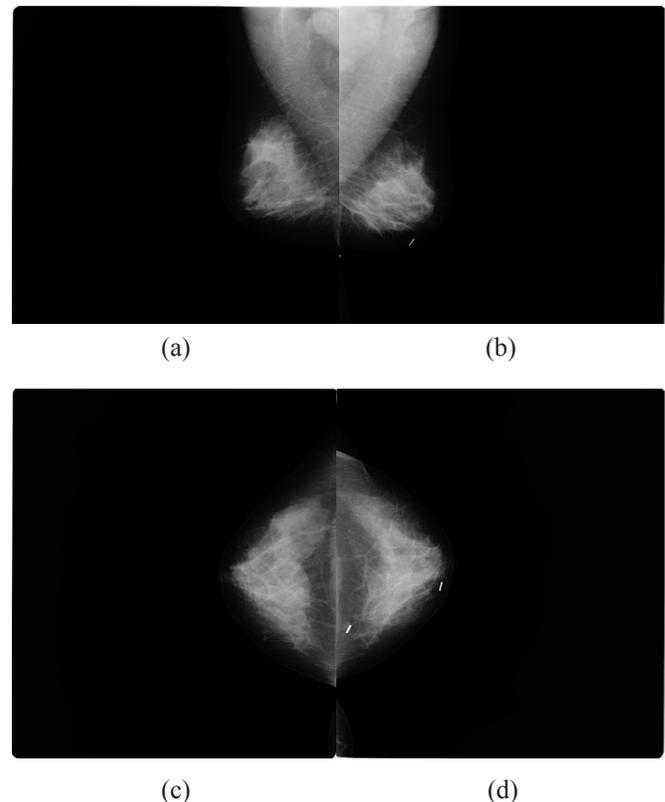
A 49-year-old woman. Mammograms in 2 standard planes: a, c – mammograms of a right breast in inclined and straight planes; b, d – mammograms of a left breast in inclined and straight plane. In the radiological conclusion, MD of breast tissue is identified as ACR BI-RADS B; the female patient is supposed to undergo a mammographic exam one more time in 2 years. The category is stated incorrectly, MD of breast tissue of this patient corresponds to ACR BI-RADS C. That means that she should make an ultrasound scan immediately.
